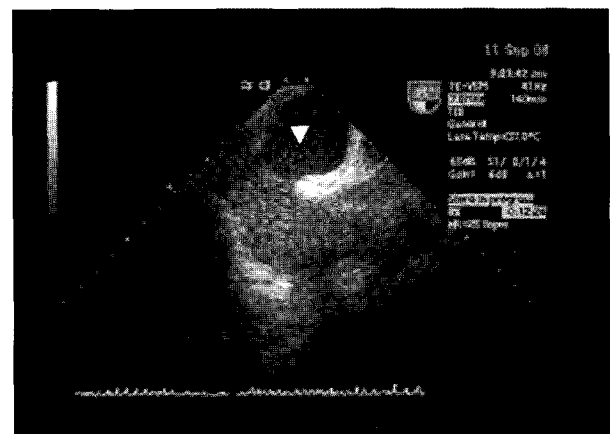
Transesophageal echocardiography (TEE) showing a small right to left shunt.
